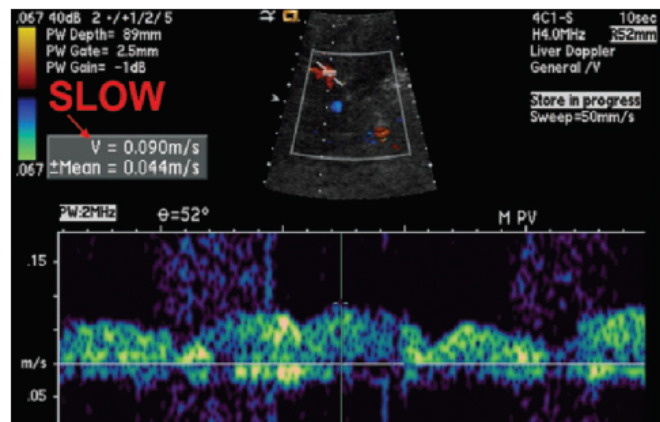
Slow portal venous flow. Spectral Doppler US image shows slow flow in the main portal vein. Slow portal venous flow is a consequence of portal hypertension. In this case, the peak velocity is 9.0 cm/sec, which is well below the lower limit of normal (16–40 cm/sec). Although portal hypertension may cause a pulsatile-appearing waveform as seen in this case, the slow flow helps differentiate this condition from hyperpulsatile high-velocity states such as CHF and tricuspid regurgitation.
